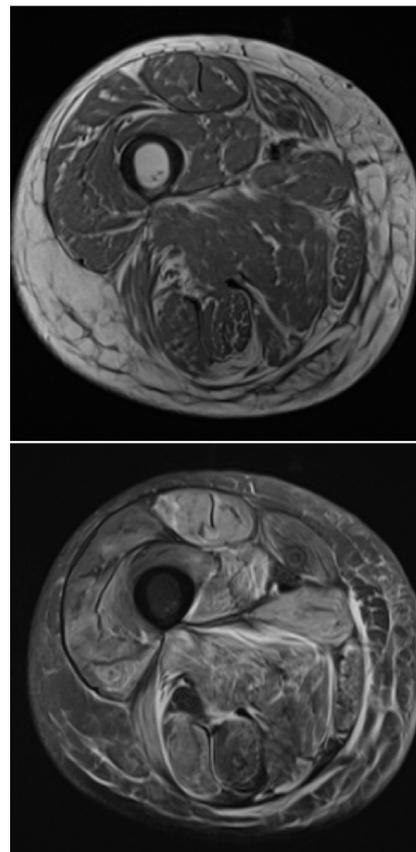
T1- (top) and T2-weighted axial MRIs of this patient's right upper leg, demonstrating diffuse edema of musculature
